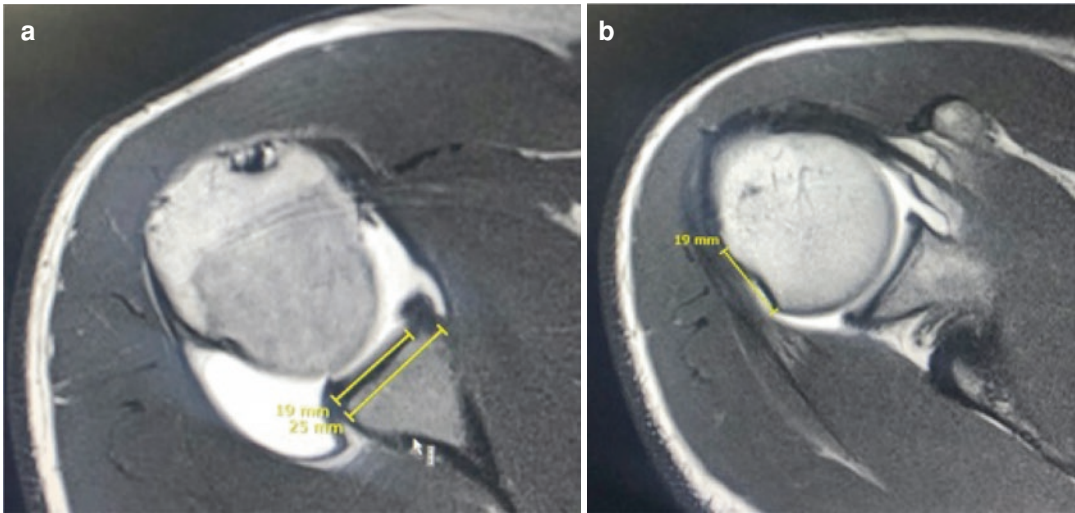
The glenoid track concept can be calculated using a CT scan or, alternatively, in an appropriately performed MR scan. Typically, the width of the glenoid would be calculated on an “en face” view of the shoulder (in this case an axial cut) (a), and the Hill-Sachs interval
